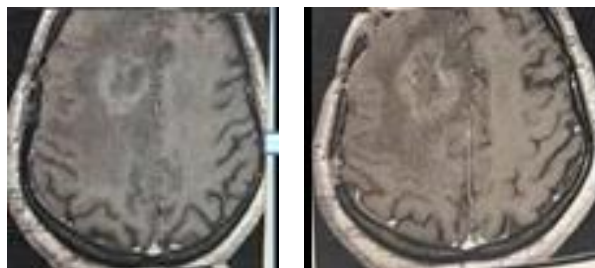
06 months post-operative MRI
